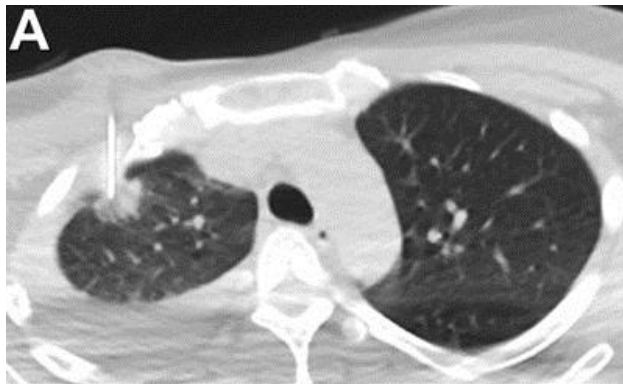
Image acquired during percutaneous transthoracic needle biopsy (A). The right pleural effusion is evident. Imaging immediately following the biopsy procedure shows a right pneumothorax (*, B).
